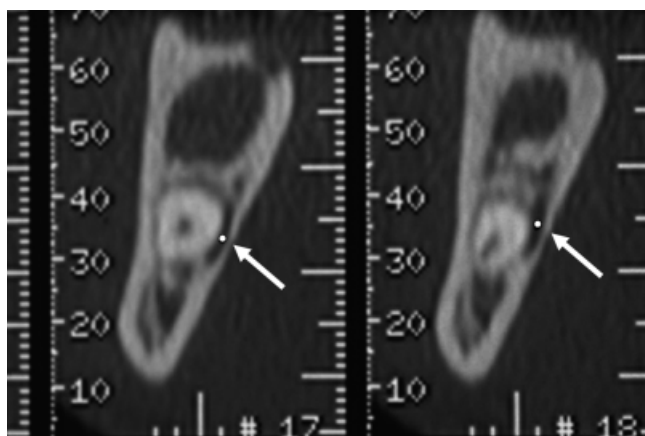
Computed tomographic scan. Note the close relationship of the mandibular third molar to the inferior alveolar nerve.
